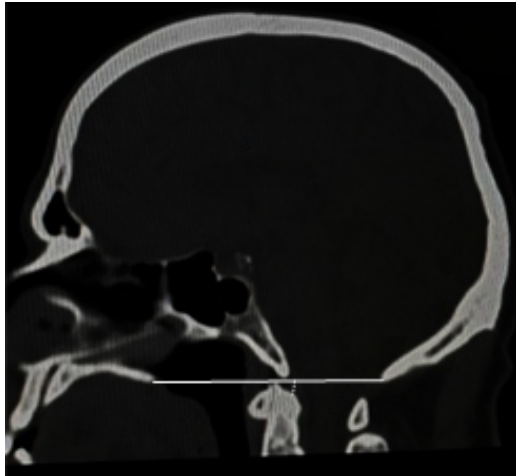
Sagittal reconstructed CT image of the brain demonstrating the measurements taken to define basilar invagination. (Solid line: Chamberlain's line; dotted line: measurement obtained from the tip of the odontoid process to the Chamberlain's line).
